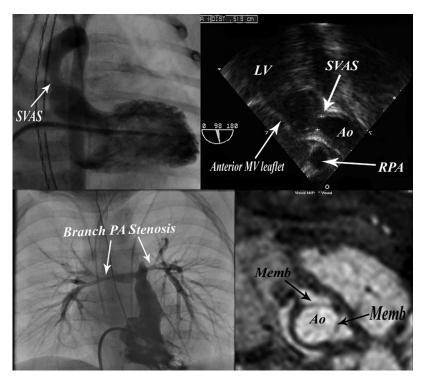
Top left: Anteroposterior projection of a left ventricular angiogram demonstrating significant supravalvular aortic stenosis (SVAS). Top right: Inverted transesophageal echocardiography mid-esophageal aortic valve long axis view demonstrating SVAS. Bottom left: Anteroposterior projection of a right ventricular angiogram demonstrating significant proximal branch pulmonary artery stenoses. Bottom right: Cardiac magnetic resonance image short axis view of the ascending aorta demonstrating an obstructive membrane arising from the sinotubular junction and extending in front of both the right and left coronary ostia in a patient with mild SVAS.
